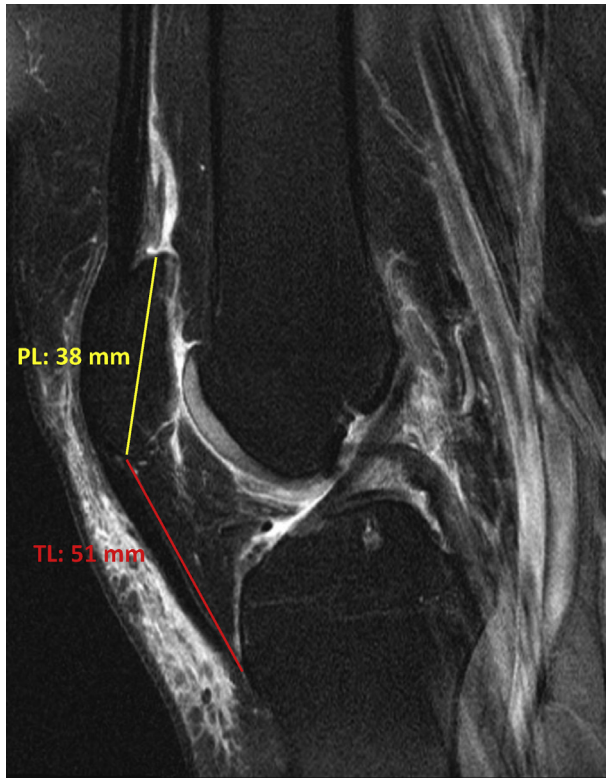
Insall-Salvati ratio measurement: IW fat-saturated TSE sequence from the knee MRI of a 58 years-old female. The Insall-Salvati ratio was calculated by dividing the length of the patellar tendon (51 mm) by the length of the patella (38 mm) in mid-sagittal MRI ($51/38 = 1.34$) with the maximum length of patella. MRI, Magnetic Resonance Imaging; IW, Intermediate-weight; TSE, Turbo Spin-Echo.
